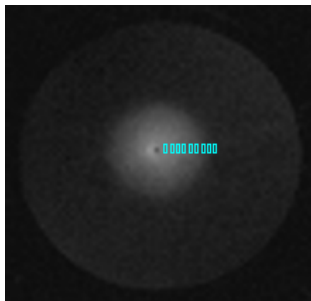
A MR image after infusion of Gd-Albumin for 91min. The infusion cannula/site was indicated by a black dot in the image center. The signal profile in the radial direction was obtained by sampling in small ROIs ( $\sim 20$  pixels in each square).
